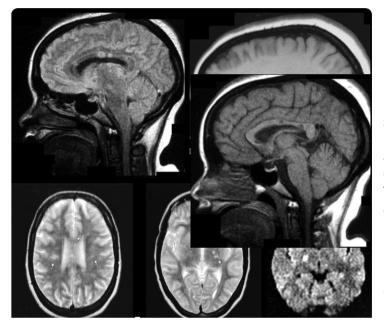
MRI in Susac Syndrome
